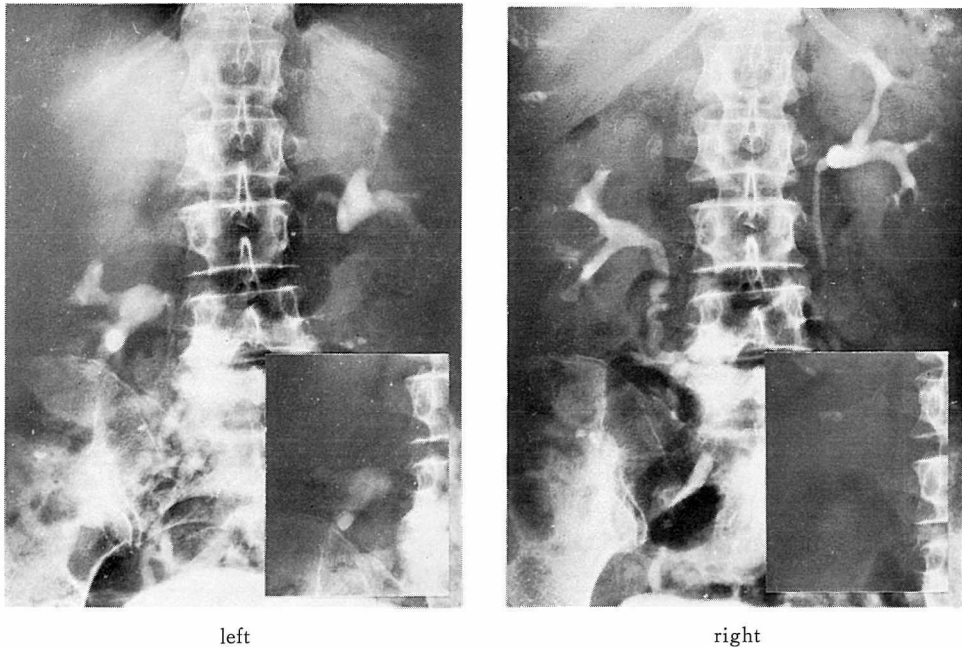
Plain films and excretory urograms before (left) and after (right) a right pyelolithotomy and a right tissue adhesive nephropexy. In upright position. The postoperative film shows that the kidney was fixed in a slightly lower than optimum position. An irregular-shaped calcific shadow overlying the right upper renal area on the postoperative plain film is identical to the extrarenal shadow on the excretory urogram.
